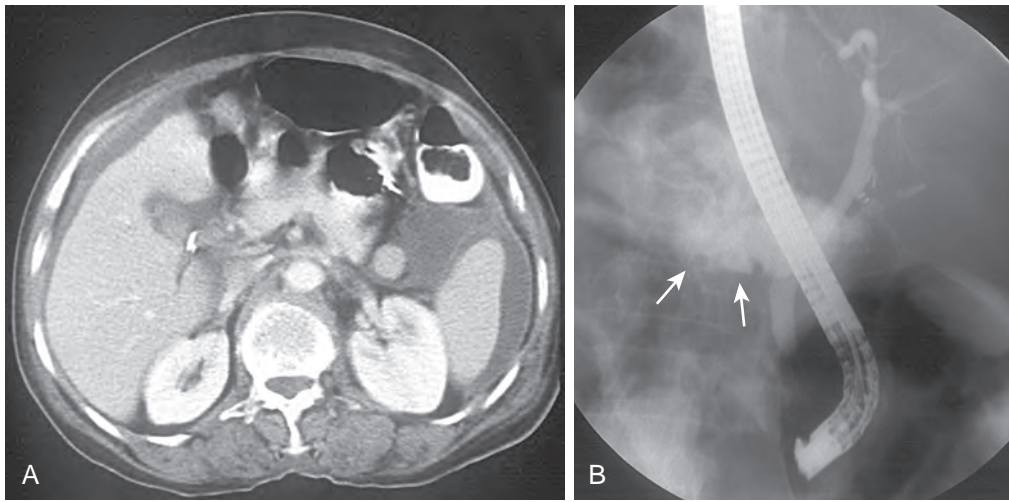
Bile leak confirmed by ERCP. A. CT obtained 5 days after LC shows free fluid in the upper abdomen mainly around the spleen and the liver and some fluid also in the gallbladder fossa, adjacent to a surgical clip. B. ERCP after the CT study shows extensive extravasation, probably from the cystic duct remnant (arrows).
